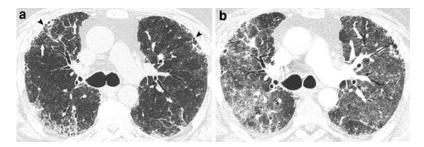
Acute exacerbation of UIP. a HRCT image shows subpleural predominant reticulation with mild traction bronchiectasis (*arrows*) and bronchiolectasis
